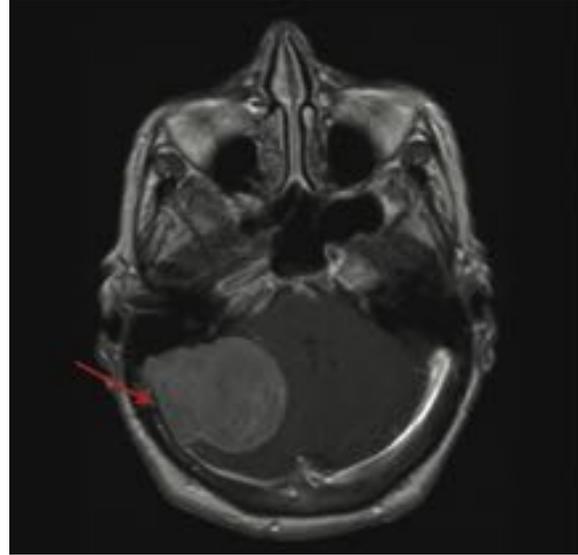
Magnetic resonance imaging of a lateral cerebellar convexity meningioma and magnetic resonance venography from a basal and lateral view demonstrating occlusion of the sigmoid sinus.
